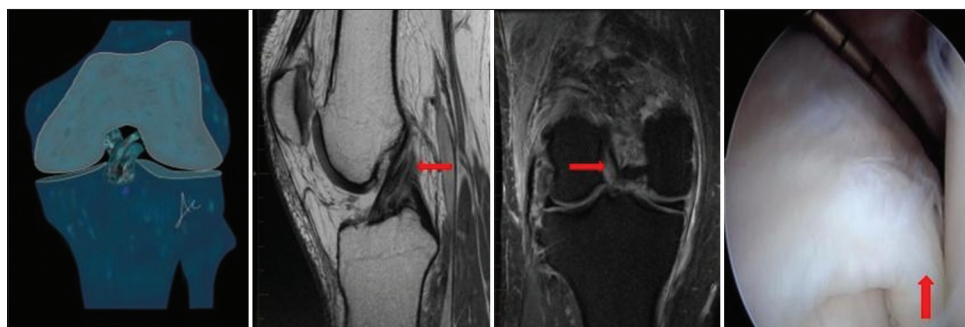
Image showing partial tear of the posterolateral bundle (red arrow) - graphical representation, sagittal oblique fluid-sensitive MRI sequence, coronal oblique fat-saturated fluid-sensitive MRI, and intraoperative arthroscopic image. MRI: Magnetic resonance imaging
